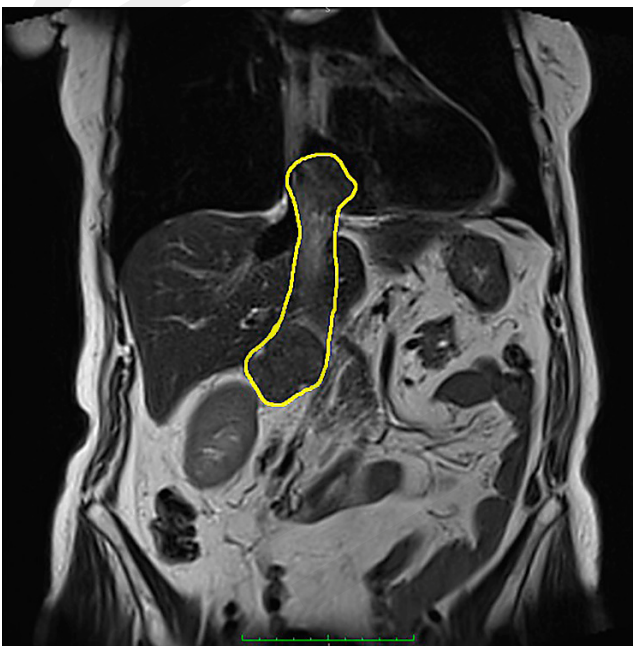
MRI image, the thrombus (yellow contour) extends into the right atrium
